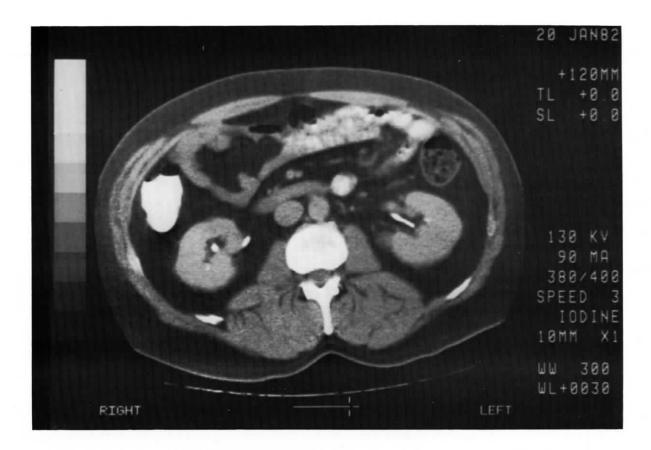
CT image produced with a video hard-copy camera.
